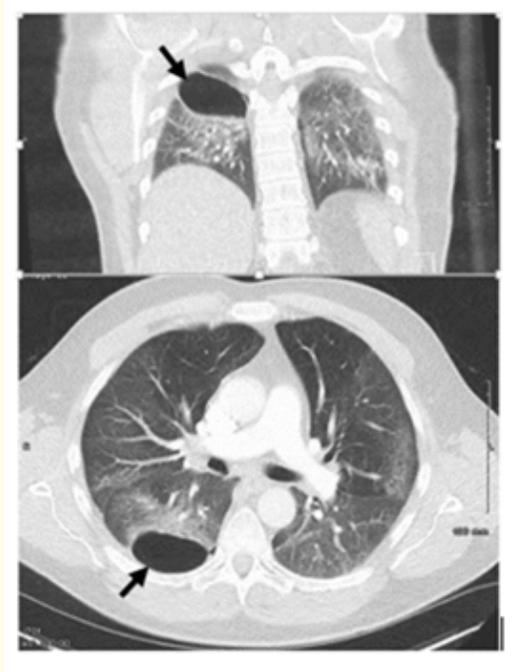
CT thorax showing evidence of right upper lobe pneumatocele (arrow). The ground glass changes and consolidation showed interval improvement.
